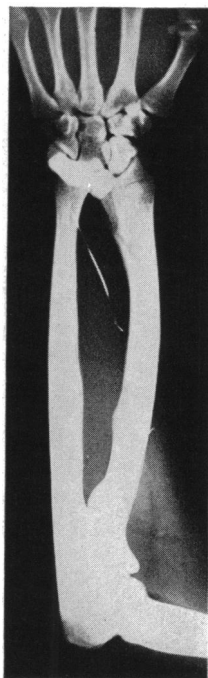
Roentgenogram of the entire forearm showing an increase in the normal lateral curvature of the radius, the rarefied area on the internal margin of the lower end of the radius, and the exostosis on its ulnar border.
